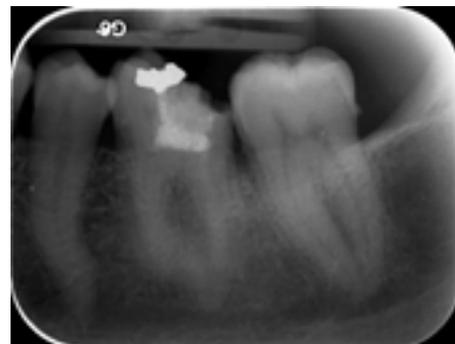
Pre-operative X-ray of 3.6.
